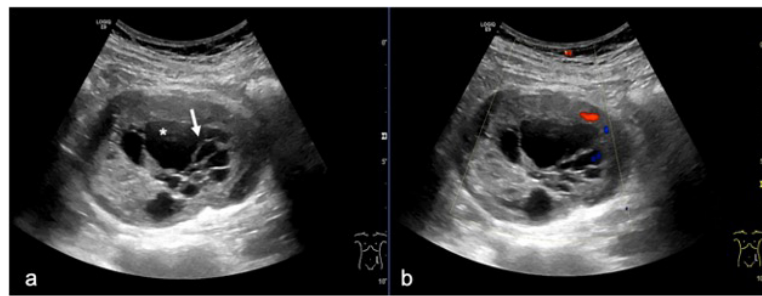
Gray scale US (a) and colour Doppler over the left flank area (b). A circumscribed, ovoid mass of mixed echogenicity, predominantly solid in the periphery with central cystic areas (*) and presence of septation (arrow) is identified. The mass shows a hypoechoic thick halo with minimal blood flow on colour Doppler US.
